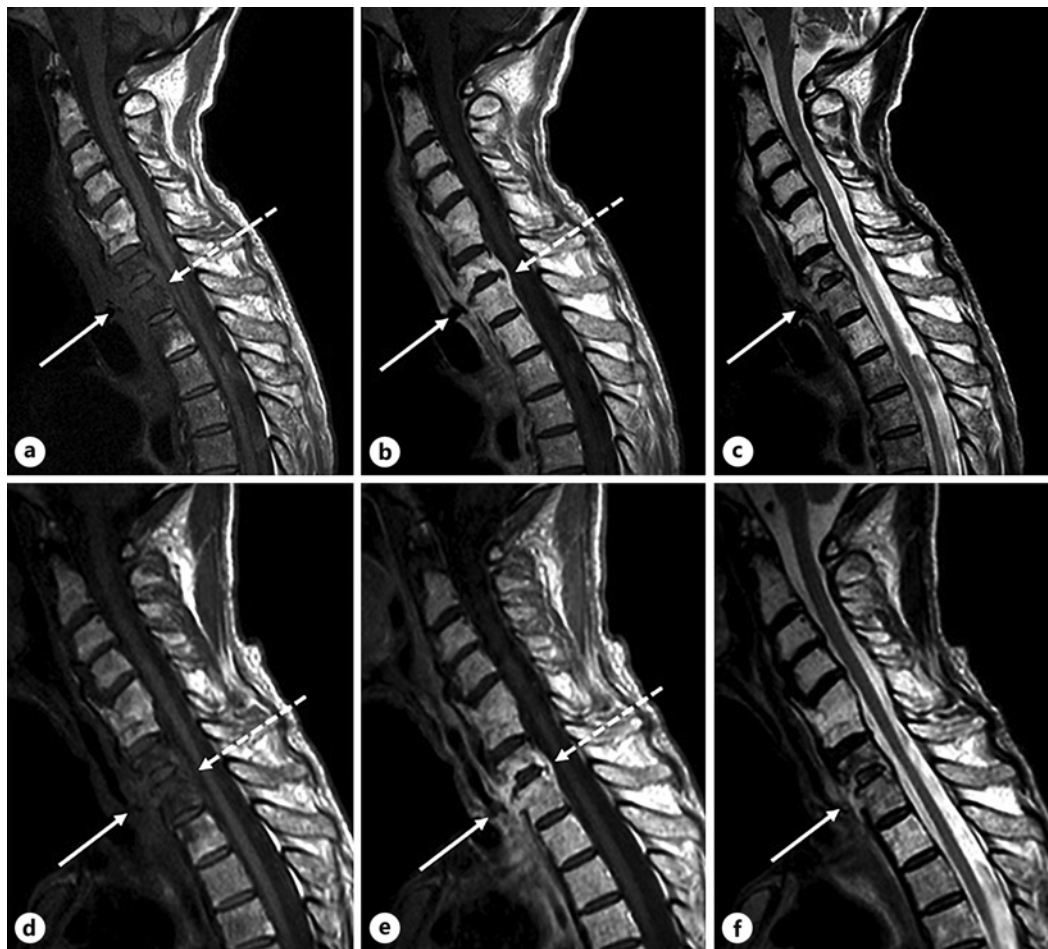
MRI sequences of the cervical spine before (images a to c) and after (images d to f) antibiotic therapy. Sagittal T1-weighted sections before (a, d) and after (b, e) gadolinium administration, T2-weighted (c, f). The initial MRI study shows the interval appearance of a radiation ulcer on the posterior wall of the hypopharynx (arrow) extending deep into the pre-vertebral space and accompanied by spondylodiscitis changes centered on the C6–C7 intervertebral. The changes consist of an epidural soft tissue mass (dotted arrow) that shows enhancement after gadolinium administration and obliterates the ventral subarachnoid space with no signs of spinal cord distress. Erosive changes of the vertebral endplates and pronounced vertebral edema from C6 to D2 are also noted. After only 2 weeks of therapy, there was a slight reduction in the depth of the ulcer, in the thickness of the epidural and peri-vertebral inflammatory mass, and no conflict with the cervical spinal cord.
